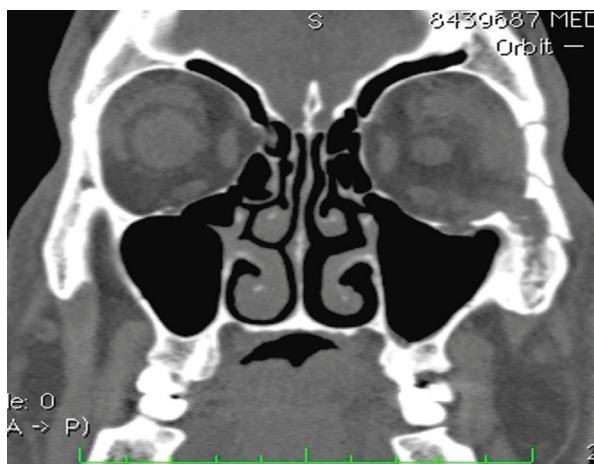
Patient, 50 y.o. Multispiral computed tomography before surgery. Front view. Posttraumatic deformity of the inferior and the temporal walls of the left orbit. Increased socket volume
